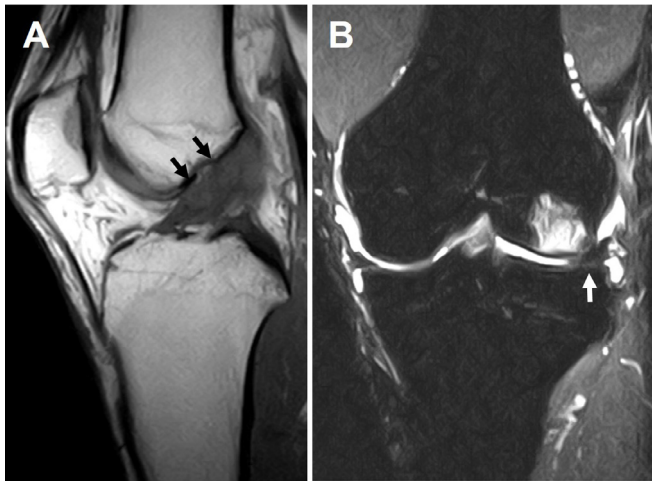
MR images before ACL reconstruction surgery. (A) Sagittal T1-weighted image shows a ruptured ACL (arrows). (B) Coronal T2-weighted image demonstrates normal and nondisplaced meniscus (arrow).
